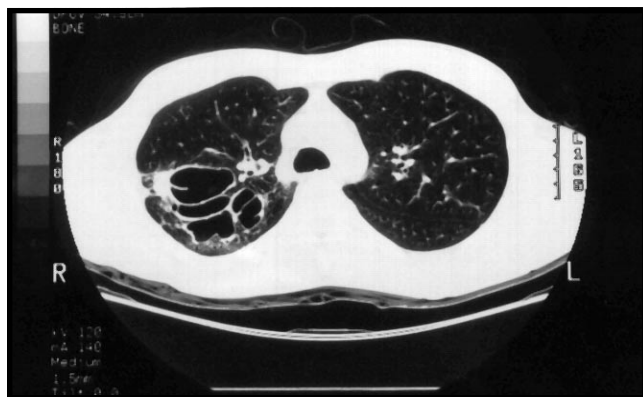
Patient 2 - Chest radiograph showed well defined thin cystic bronchiectatic changes surrounded by mild parenchymal infiltrates at the right upper lobe.
